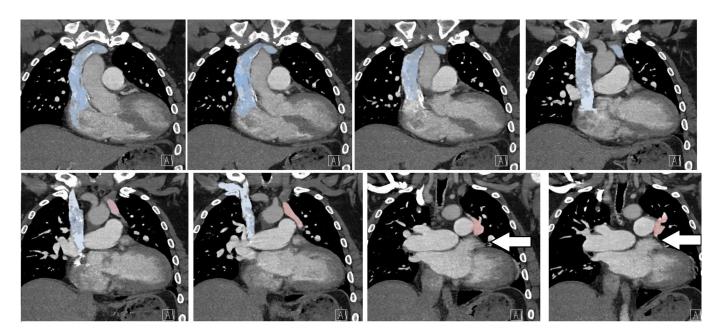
Coronal CT angiography sequential series showing the course of the brachiocephalic vein joining with the superior vena cava (blue) and the anomalous drainage of the left pulmonary vein into the brachiocephalic vein (red). Note: The arrow shows the lack of pulmonary veins entering the left atrium.
